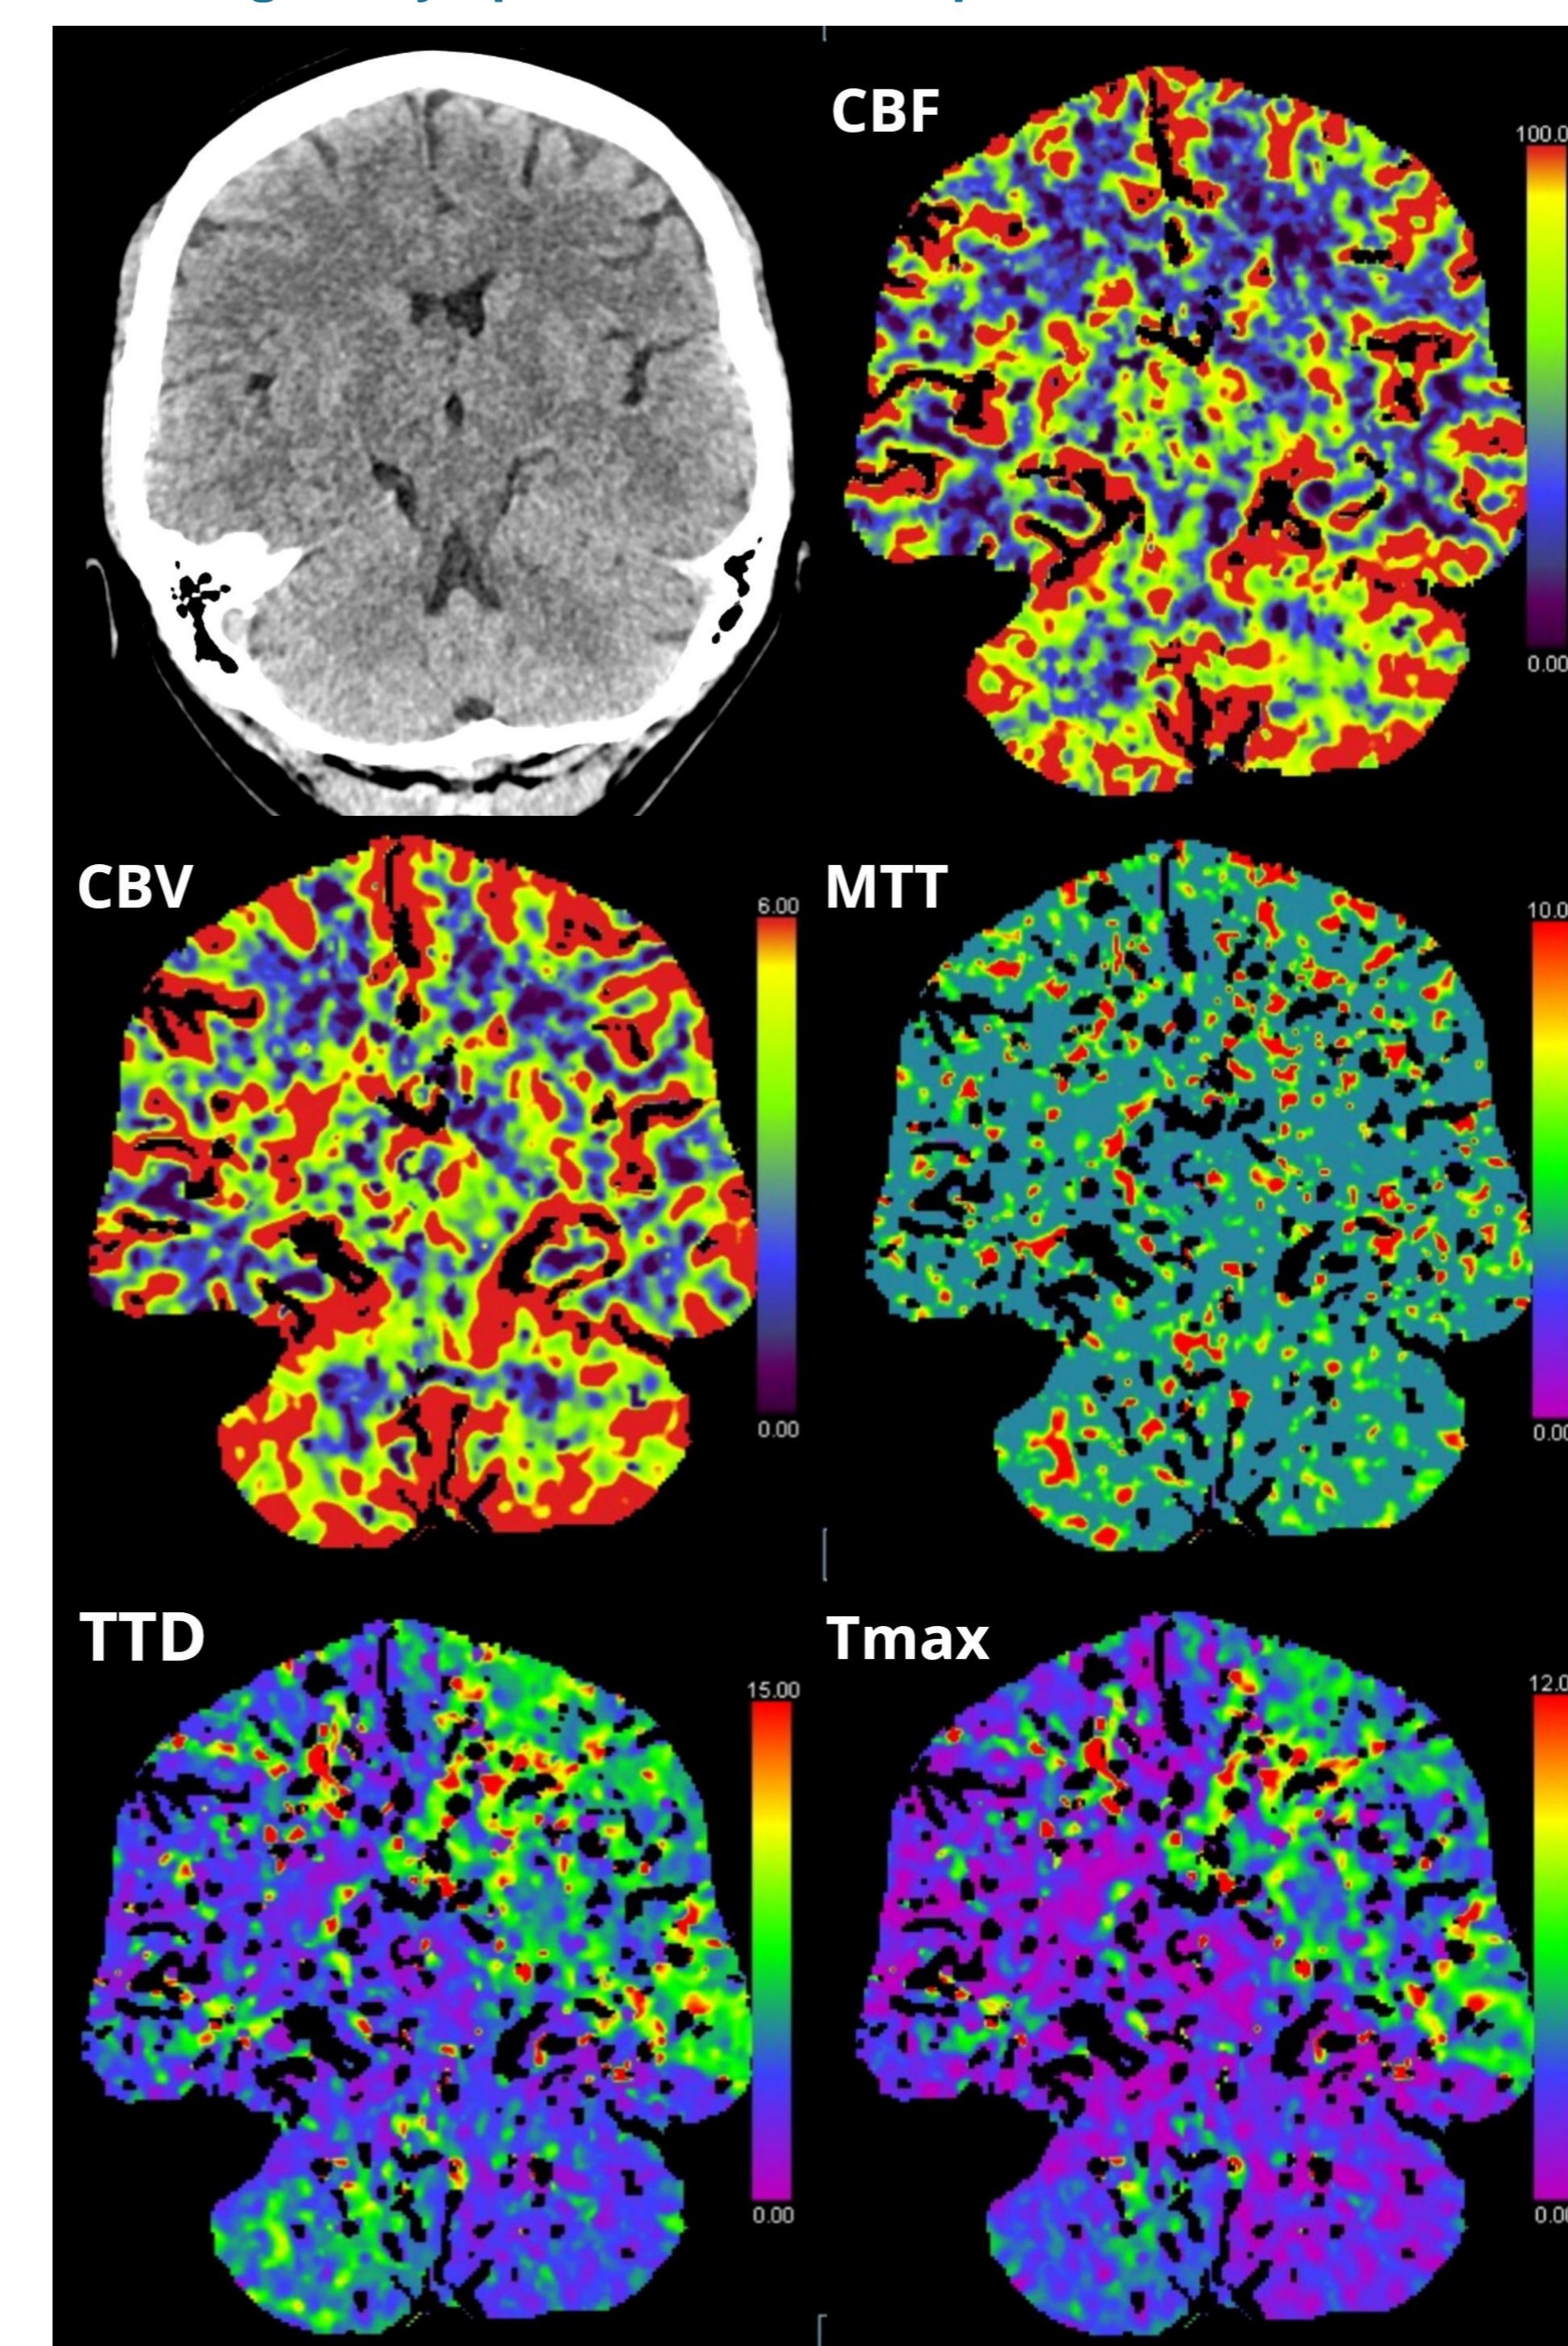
Results of brain CT perfusion on the 7th day after the operation.
